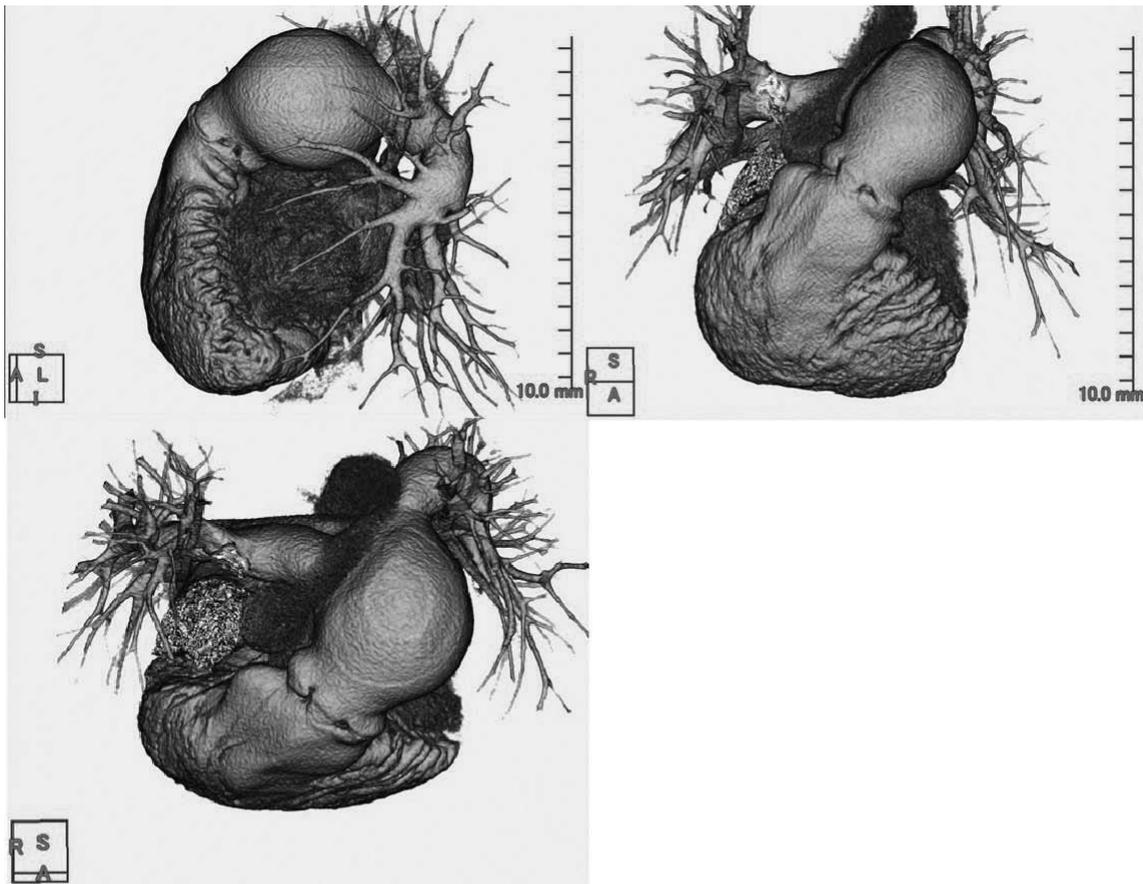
Three-dimensional reconstruction of chest computed tomography. Shown here is diffuse aneurysmal dilation of the pulmonary artery.
